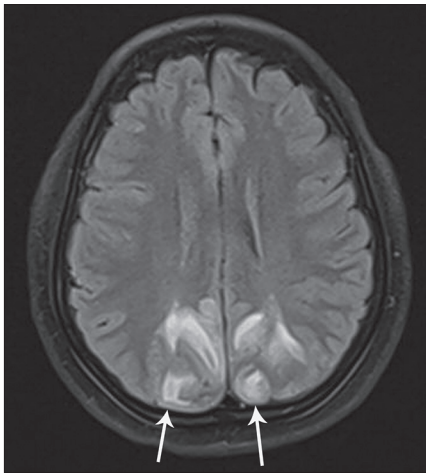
Axial MR image (fluid attenuated inversion recovery) showing confluent edema in subcortical and deep white matter (Grade 4) seen as hyperintensities in bilateral parieto-occipital lobes (patient 6)
